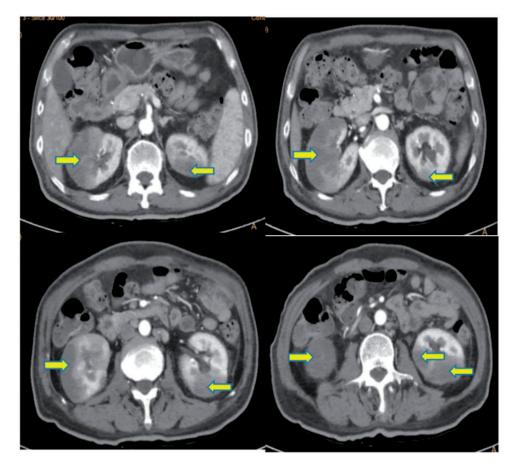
Imaging of renal infarcts. Contrast-enhanced CT demonstrating multiple low-attenuation areas in both kidneys (arrows).
